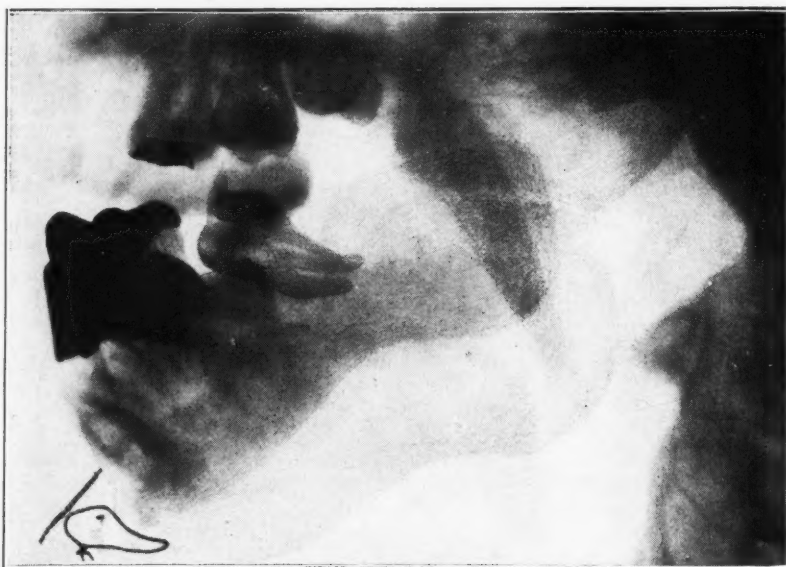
X-ray showing condition of the ramus some time after section. Notice the obliquity with which the part of the ramus above the saw cut meets the lower portion. In this case there was no operation performed on the ankylosed joint, and on that side there is only a fibrous union between the divided parts of the ramus. Later this union became so close that it was necessary to excise the ankylosed joint. The nail and wire at the chin were used to hold a piece of costal cartilage in place.
